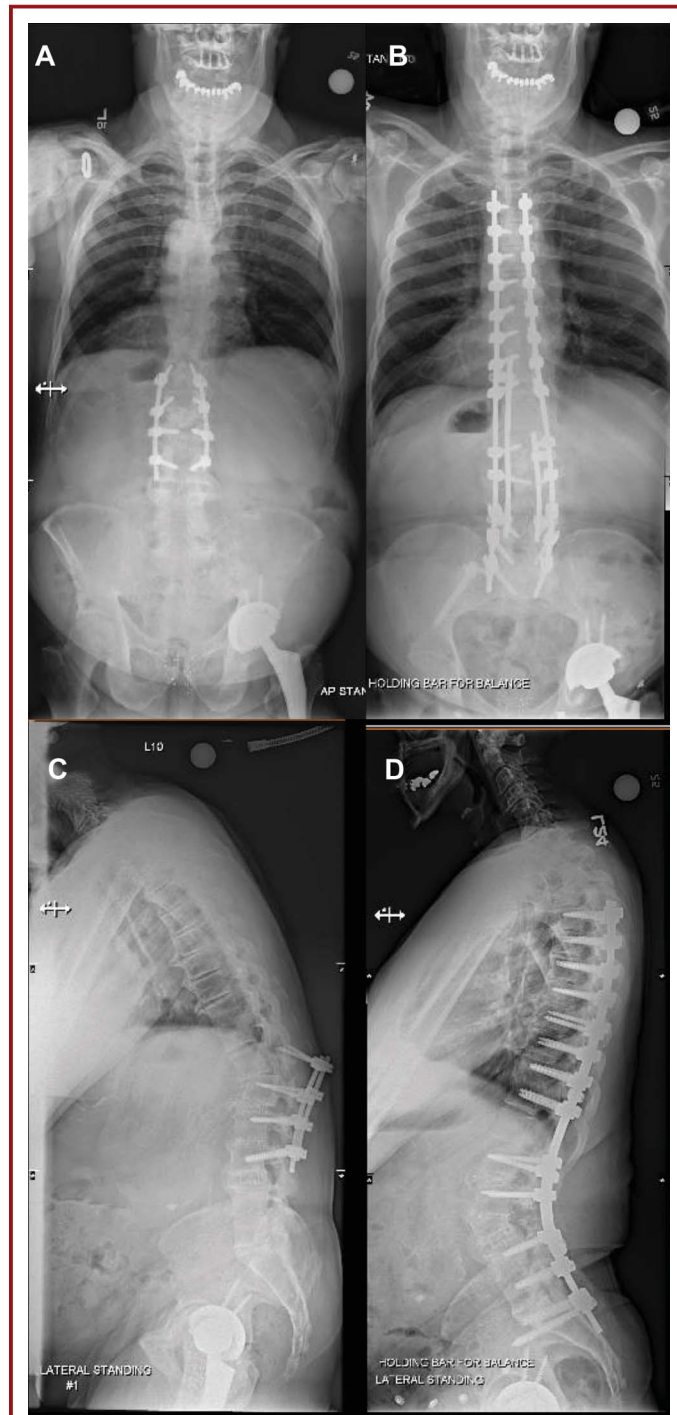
Standing long-cassette radiographs of a 72-year-old female with severe back pain and inability to stand upright show degenerative kyphoscoliosis. A, preoperative lateral view demonstrates severe sagittal malalignment with sagittal vertical axis of 18 cm. Thoracic kyphosis of 66 degrees was present, necessitating a proximal thoracic upper instrumented vertebra. B, postoperative lateral radiographs following T4 to ilium instrumented fusion with multiple thoracic and lumbar Smith-Petersen osteotomies demonstrates improved global alignment with reduction of thoracic hyperkyphosis.
